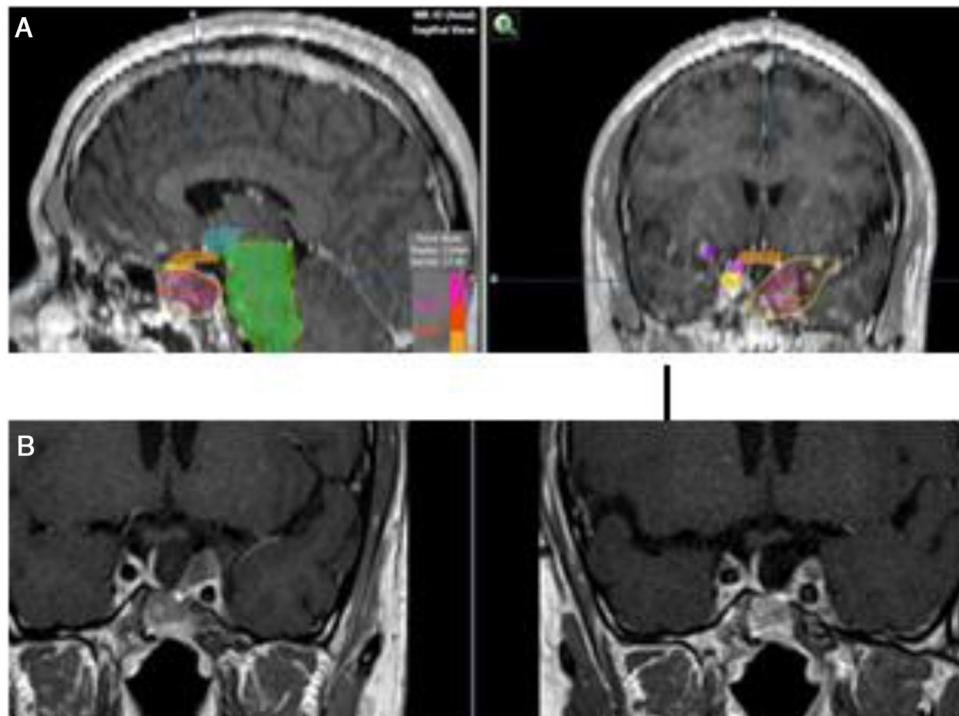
(A) Re-irradiation in a patient with non-functioning adenoma not controlled neither with surgery nor with RT (previously he had received IMRT 50 Gy). Dose distribution with FSRT and IMRT (46.8 Gy in 26 fractions). The patient received concomitant therapy with RT and TMZ 75 mg/m² and subsequently 6 cycles of adjuvant TMZ. (B) Pituitary MRI appearances (T1 postgadolinium weighted coronal images). Before (left) treatment and after (right) concurrent therapy with TMZ and radiotherapy. Early response is appreciated.
